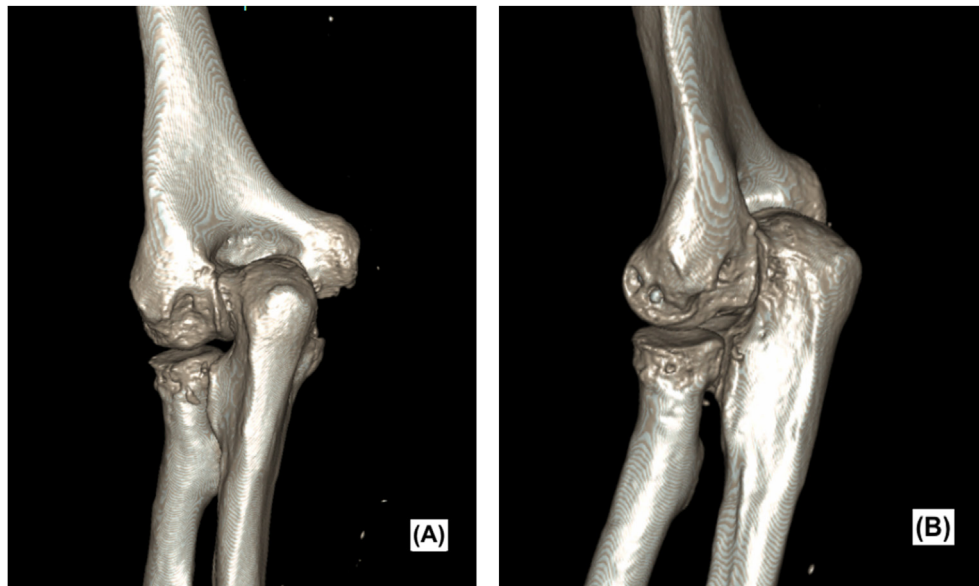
6 months postoperative computed tomography with 3-Dimensional reconstruction (A) and (B) of the elbow showing correct articulation of the radiocapitellar and ulnohumeral joints and highlighting the posterior capitellar osteochondral defect induced by the initial impact of the radial head.
